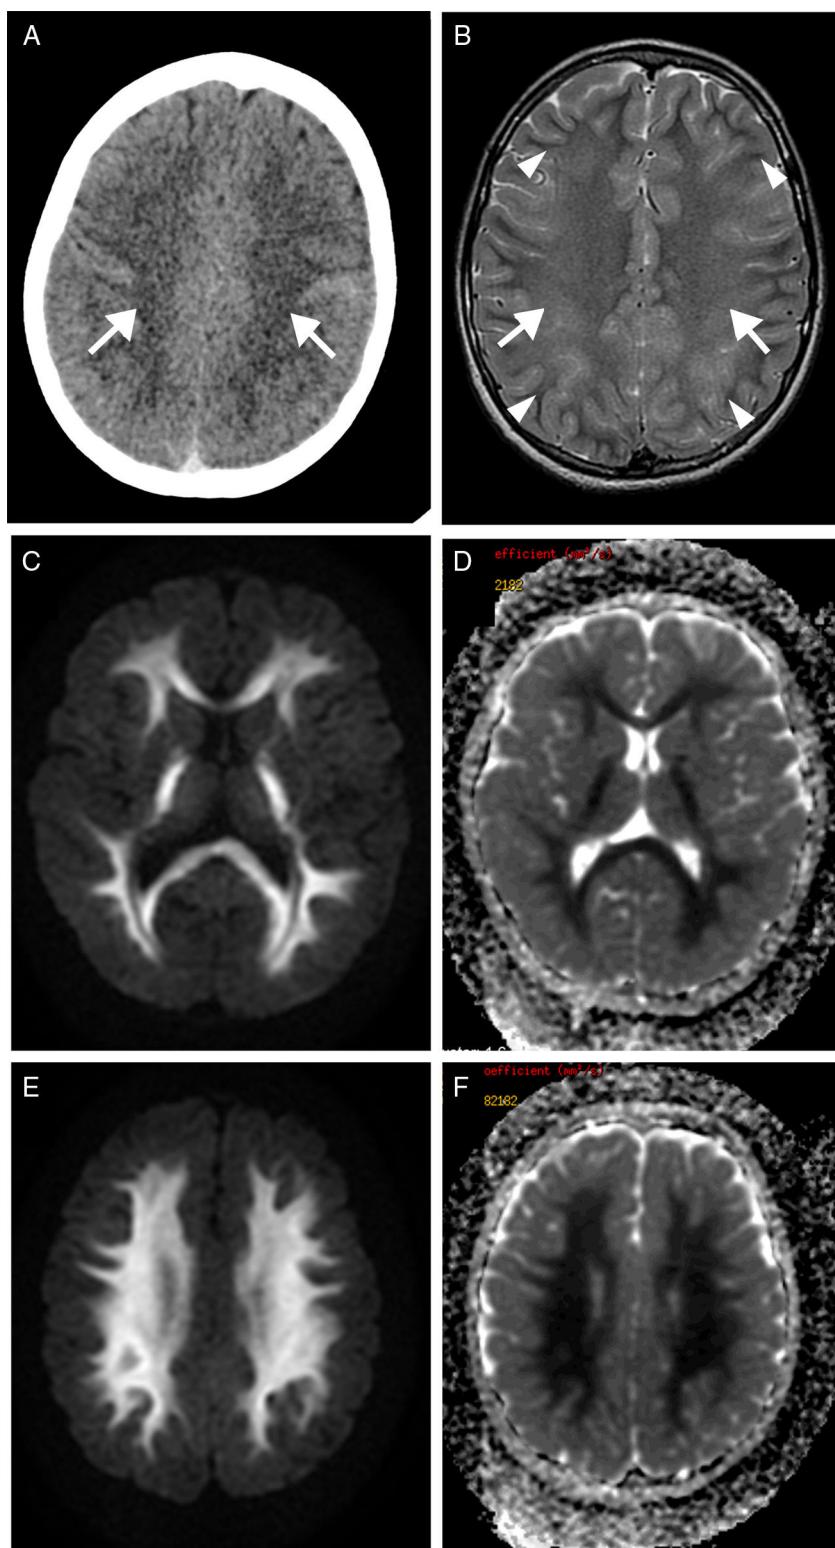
Transverse CT sequence (A) showing a faint hypodensity in the supratentorial white matter (arrows). Transverse T2-weighted MRI sequence (B) showing homogeneous hyperintensity of the supratentorial white matter, confluent with bilateral and symmetrical distribution (arrows), sparing the U fibres (arrowheads). Diffusion restriction is observed on the diffusion sequence (C and E) and corresponding apparent diffusion coefficient maps (D and F).
